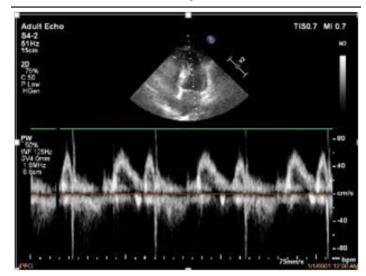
Transmitral doppler at the level of the lateral mitral ring; the diastolic disfunction of the left ventricle can be evaluate.
